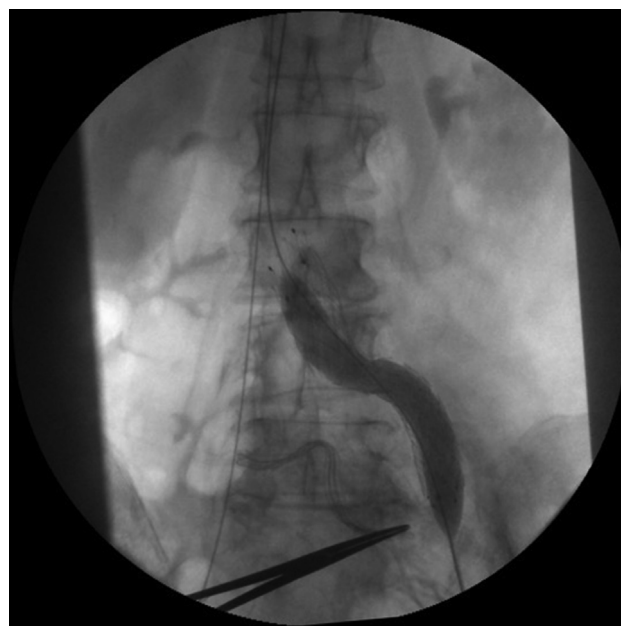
Xray at the end of the first procedure.
